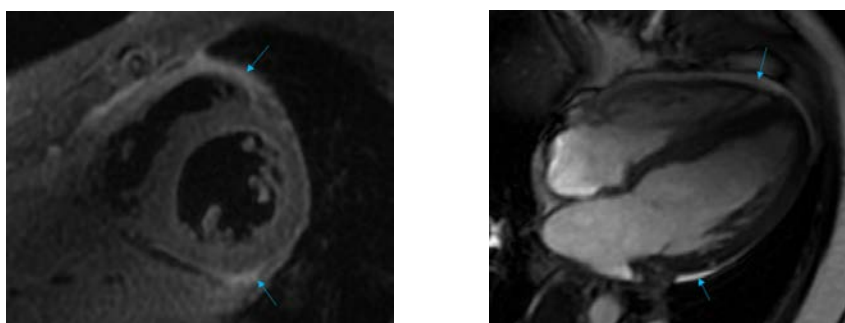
Cardiac magnetic resonance imaging, T2-weighted black blood triple inversion recovery sequence, short-axis view: signal of the myocardium is normal, no signs of edema. Pericardial effusion - hypersignal area (arrows, left picture). Cine bright blood sequence, four-chamber view; pericardial effusion – hypersignal area (arrows, right picture).
